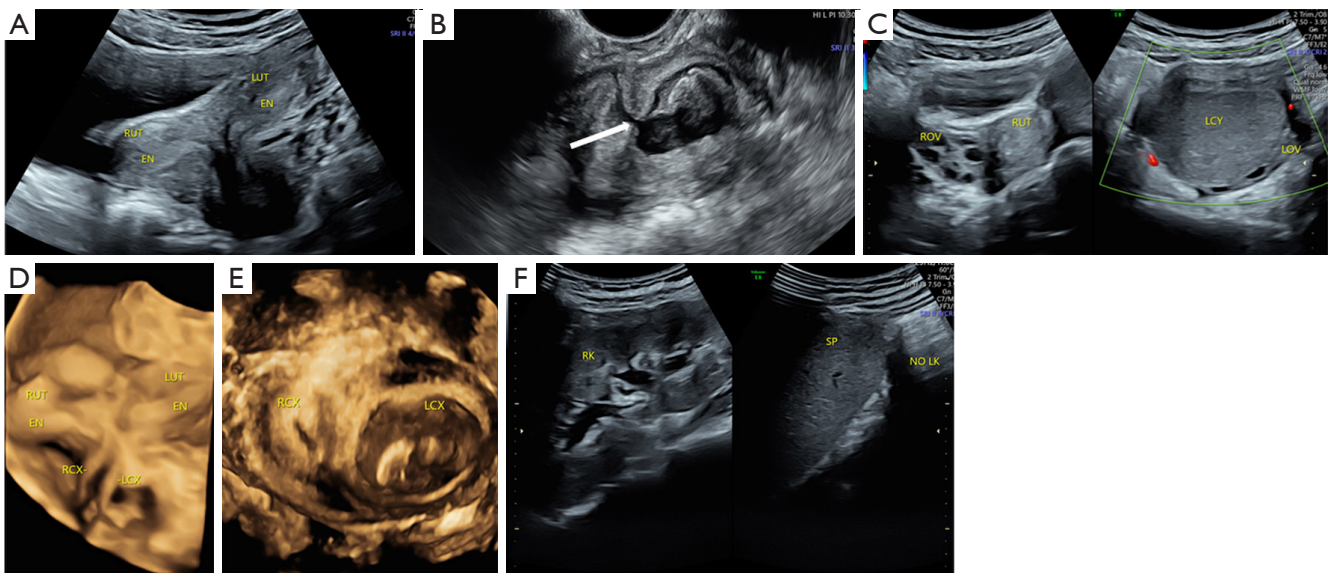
Type III UGTOIRA syndrome: U3c-C3b-V0, bicorporal septate uterus, septal cervix with left obliterated external cervical orifice, a fistula on the cervical septum, hemorrhage filling in the left cervical canal, a normal vagina, left ovary with an endometriotic cyst, and left renal agenesis. Sonograms were obtained from a 17-year-old female patient. (A) TAS 2D coronal plane demonstrating a bicorporal septate uterus and septal cervix. (B) TRS 2D cross-section of the cervix demonstrating the fistula on the cervical septum (the arrow indicates the fistula). (C) TAS 2D ovarian sagittal planes demonstrating a normal right ovary (left side of the figure) and an endometriosis cyst within the left ovary (right side of the figure). (D) TAS 3D coronal plane of the uterus-cervix under stereoscopy demonstrating a bicorporal septate uterus and septal cervix with left obliterated external cervical orifice and hemorrhage filling in the left cervical canal. (E) TRS 3D coronal plane of the cervix under stereoscopy demonstrating a septal cervix with left obliterated external cervical orifice and hemorrhage filling in the left cervical canal. (F) TAS 2D sagittal planes identifying the absence of the left kidney (NO LK; right side of the figure) and a normal right kidney (RK; left side of the figure). RUT, right uterus; LUT, left uterus; EN, endometrium; ROV, right ovary; LCY, left ovarian cyst; LOV, left ovary; RCX, right cervix; LCX, left cervix; RK, right kidney; SP, spleen; LK, left kidney; UGTOIRA, unilateral genital tract obstruction with ipsilateral renal anomaly; TAS, transabdominal sonography; TRS, transrectal sonography; 2D, 2-dimensional; 3D, 3-dimensional.
